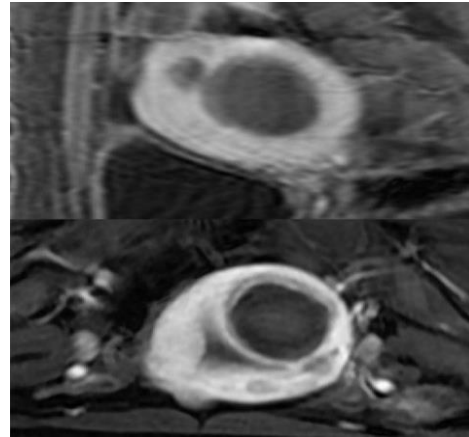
Enhanced MRI did show the ablation zone after MRgFUS
